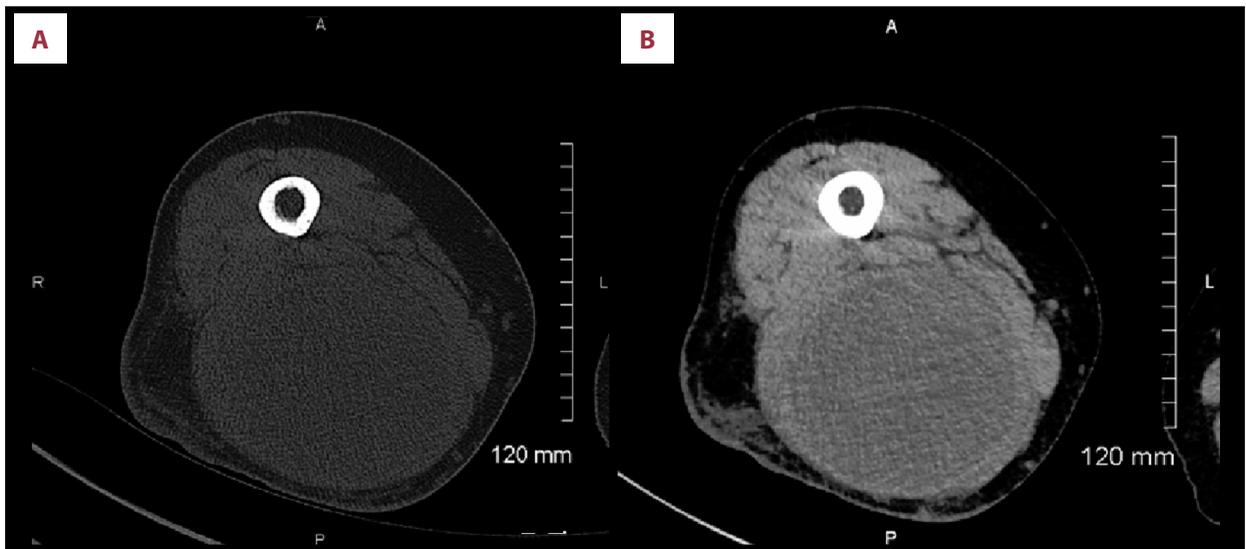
CT scan of the lower extremity without (A) and with (B) contrast demonstrating the bulk of the tumor.
